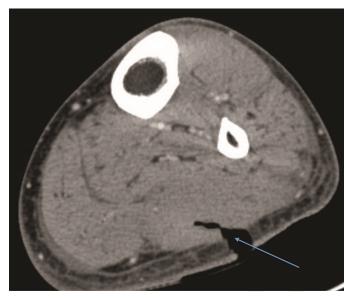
Lower extremity computed tomography scan with intravenous contrast showing collapse of the abscess cavity after incision and drainage.
